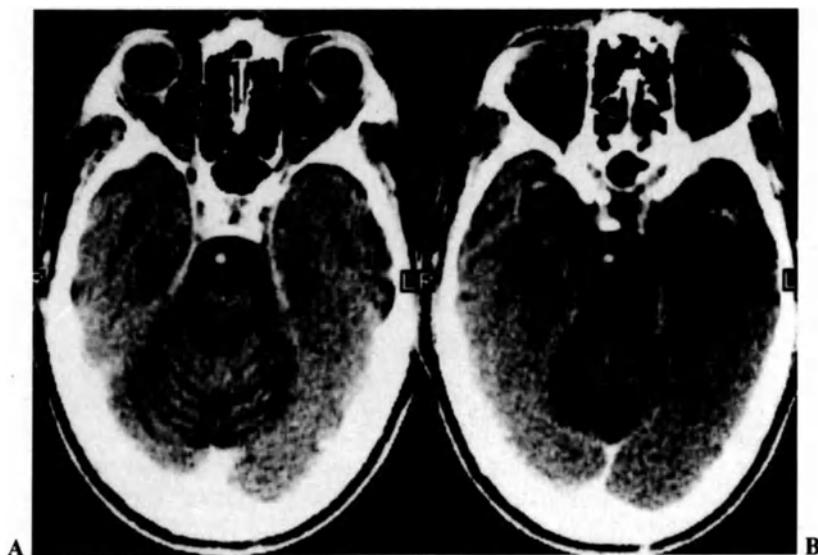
CT showing focal atrophy of cerebellum and brainstem.
